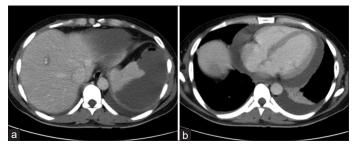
Computed tomography abdomen (a) Splenic abscess and liver (segment VII) abscess; (b) Moderate pericardial effusion
